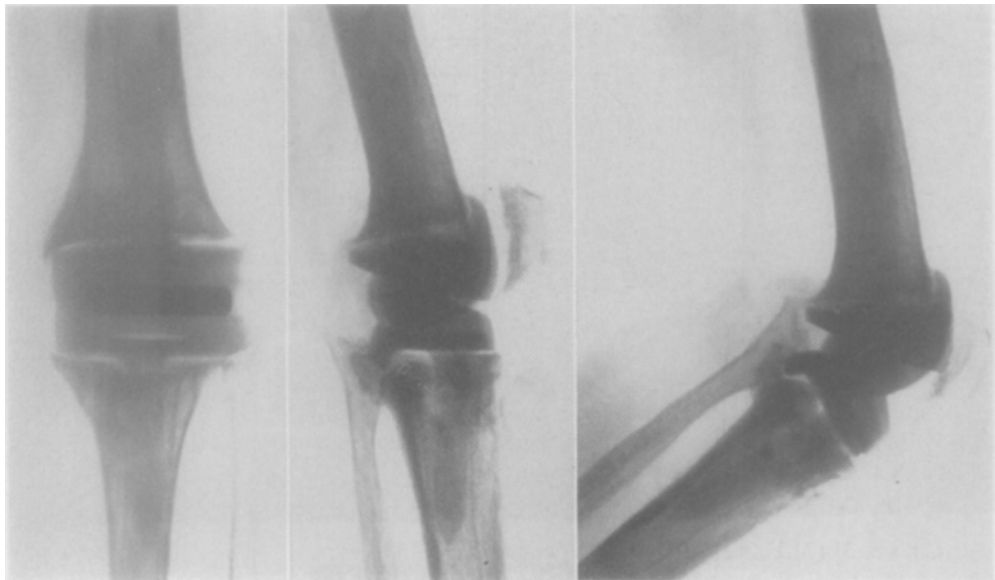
Case 2: roentgenograms 3 months after reoperation (insertion of new prosthesis).
